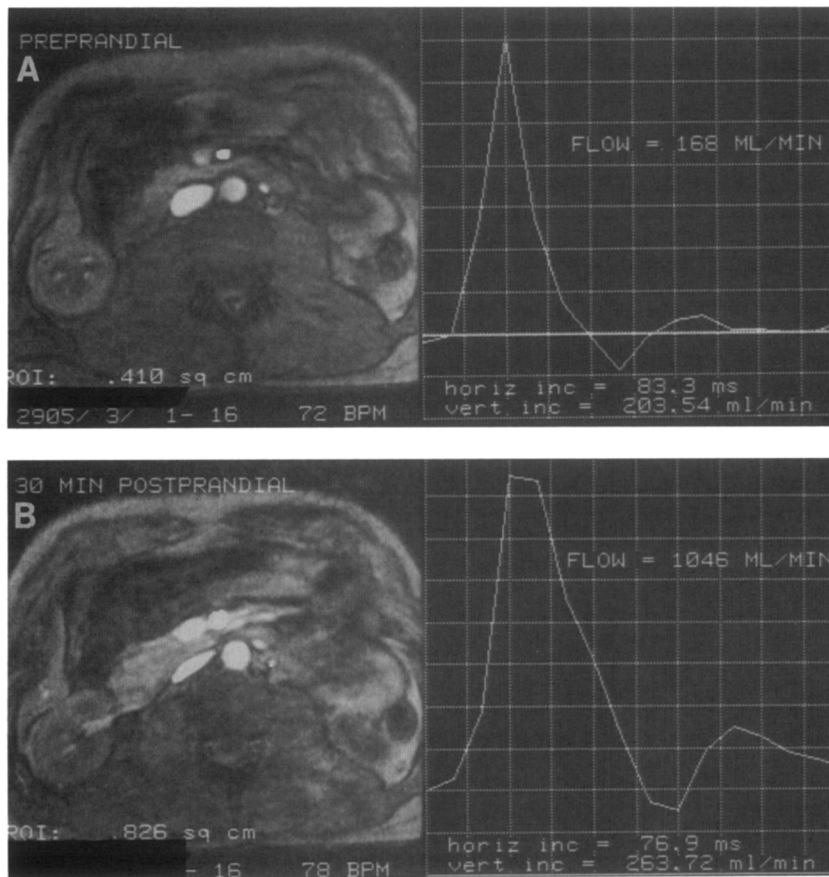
Cine PC MR images obtained with cardiac gating and plots of SMA blood flow in a healthy subject (A) before and (B) 30 min after food intake. Note the low SMA blood flow and the reverse early diastolic flow in the fasting state. There is a marked increase in SMA blood flow 30 min after food intake, and the reverse early diastolic flow has disappeared. (Reprinted with permission.¹⁷)
